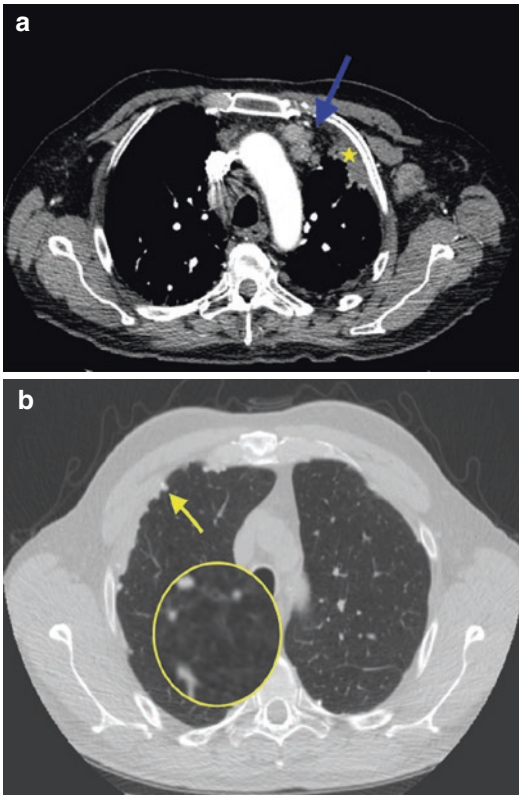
(a, b) 70-Year-old man who worked for 30 years in a shipyard. High-resolution axial unenhanced CT image (lung windowing) highlighting multiple nodular pleural thickening (yellow arrow) and centrilobular (magnified)
